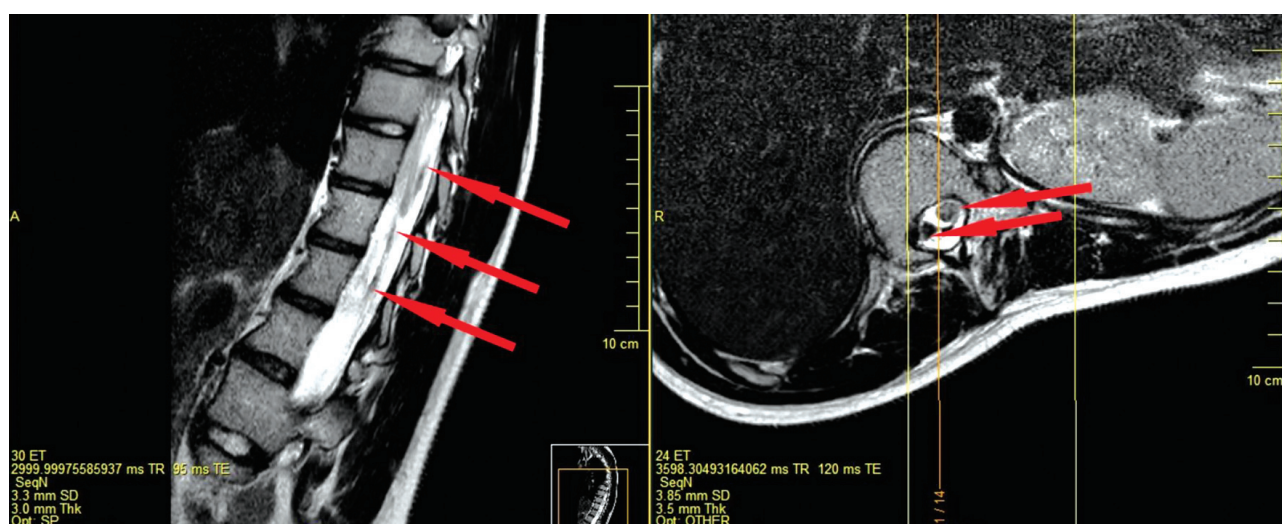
MRI scan of the spinal cord performed during the recovery period. Sagittal and axial T2W_TSI images showing cystic-glia changes, atrophy of the spinal cord at the Th10–12 level and adhesions in the dural sac
